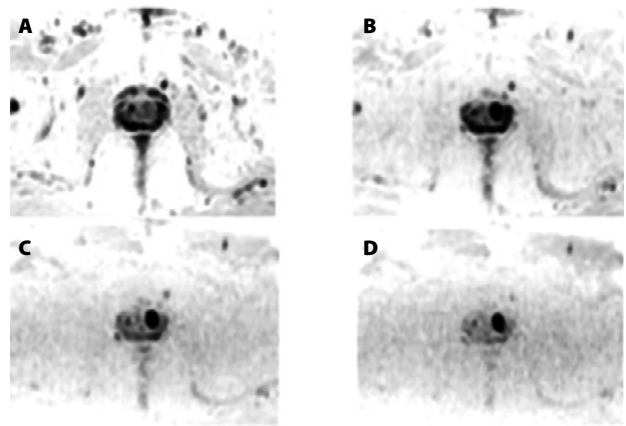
Axial MR images (b values of 0 s/mm^2 [A], 500 s/mm^2 [B], 1000 s/mm^2 [C] 1400 s/mm^2 [D]) of a hypointense lesion. Images courtesy of author.
